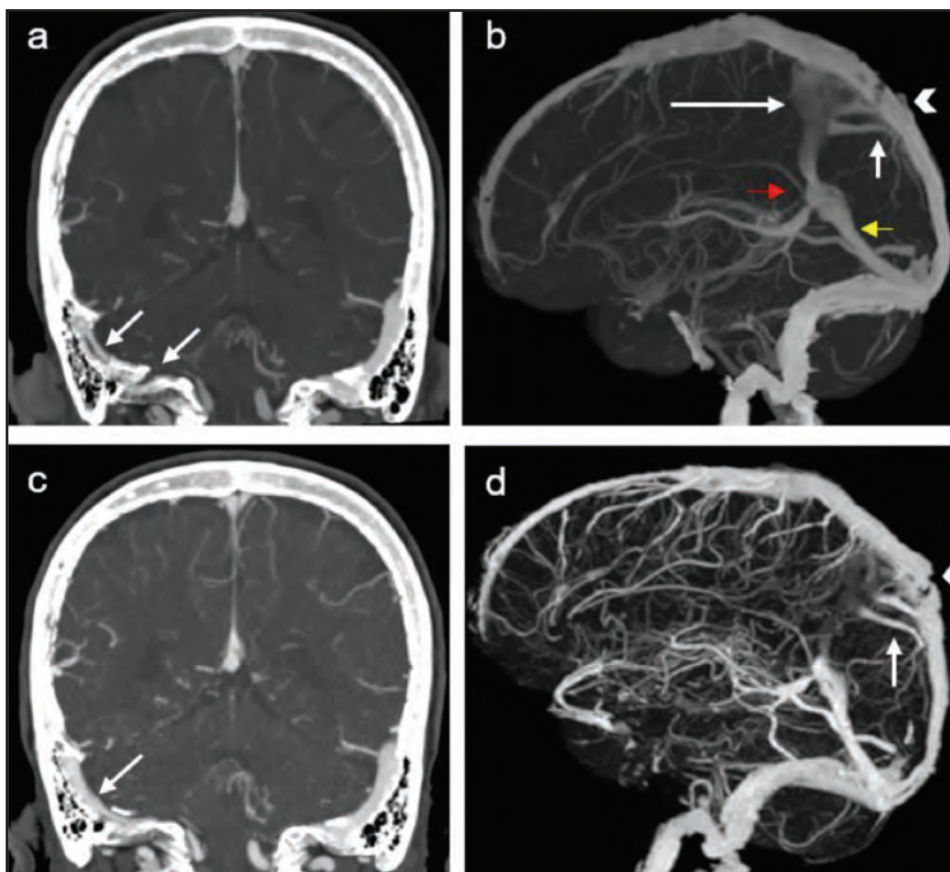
An 81-year-old woman with known thyroid carcinoma presented with severe headache for 1 month. Coronal CT cerebral venogram image (a) shows filling defects in the right sigmoid sinus and right internal jugular vein (IJV), which is consistent with venous sinus thrombosis (short arrows). Sagittal maximum intensity projection (MIP) CT venogram image (b) shows recanalisation of the falcine sinus (long arrow) connecting the vein of Galen (red arrow) and the straight sinus (yellow arrow) to the superior sagittal sinus. There are two short linear collateral vessels (short arrow) connecting the falcine sinus (long arrow) to the posterior part of the superior sagittal sinus (arrowhead). After 6 weeks of anticoagulant therapy, the coronal CT venogram image (c) shows partial recanalisation of the right sigmoid sinus and IJV thrombosis. Sagittal MIP CT venogram image (d) shows reduced flow in the falcine sinus. There are persistent short linear collateral vessels (short arrow) connecting the faintly opacified falcine sinus to the posterior part of the superior sagittal sinus (arrowhead)
